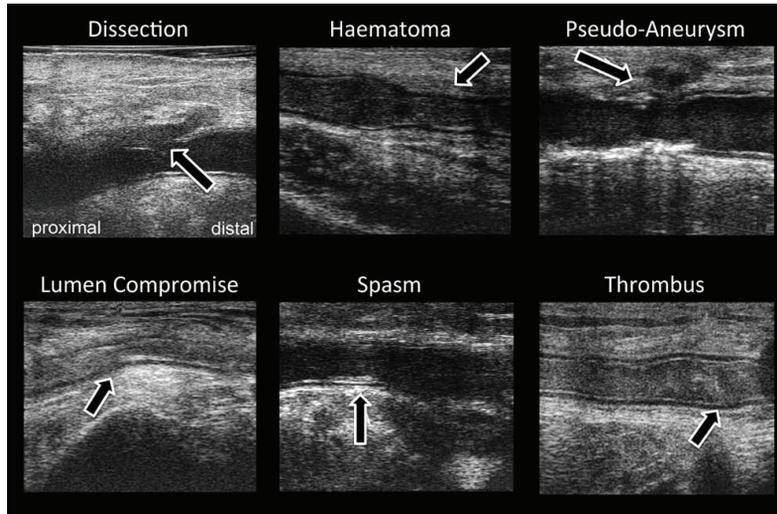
Ultrasound evidence of radial artery acute wall injuries at puncture site. Radial dissection: The arrowhead indicates the disruption of the vessel layers at the longitudinal view. Wall hematoma: the arrowhead indicates the hematoma with evidence of blood between the vessel layers. Pseudoaneurysm: arrowhead indicates the pseudoaneurysm at the longitudinal view, with evidence of blood outside the vessel wall. Lumen compromise: compromise of the arterial lumen caused by any injury. Spasm: the arrowhead indicates spasm, shown as vessel shrinkage and a thickened intima. Thrombus: arrowhead indicates the thrombus presenting as a still mass in the vessel lumen, characterized by the clear transition between its surface and the intima.
